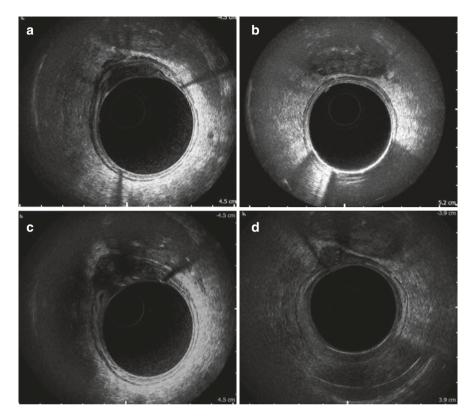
(a) An uT4 tumour invading the prostate with peri rectal hypoechoic lymph node. The bright layer of Dennonvillier's fascia is clearly seen to be disrupted. This tumour was treated with long course chemoradiotherapy. (b) The same tumour after treatment with complete clinical, radiological and pathological response with now a normal ultrasonic appearance of the rectum and prostate. (c) Further anterior images confirm a sizeable recurrence clearly breaking the hyper-echoic submucosa and re-infiltrating the fascia of Denonvilliaers just below the prostatic capsule. (d) The same tumour after careful clinical, endoscopic and radiological review now showing reemergence of the tumour on the anterior rectal wall
